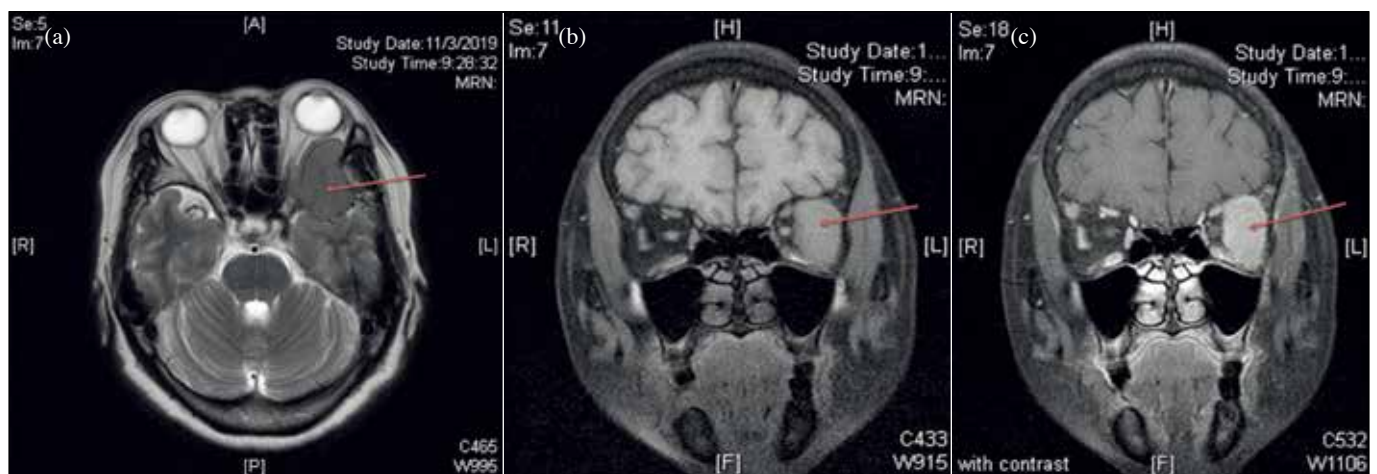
Magnetic resonance imaging showing a left orbital mass in (a) T2-weighted axial view, (b) T1-weighted coronal view, (c) and T1-weighted coronal view with homogeneous contrast enhancement
